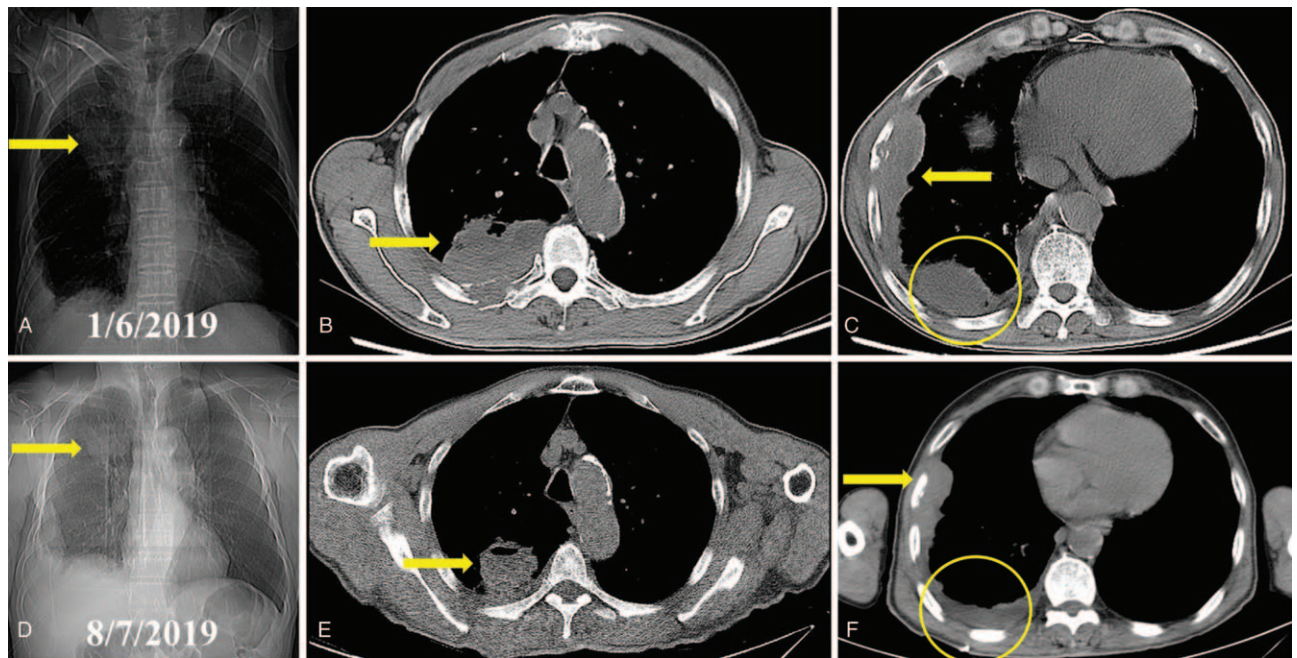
Radiological images of the thoracic lesions (indicated by arrow and circle) before and after systemic treatment in case 3. A. The X-ray showed a bulky mass located in right upper thorax. B. Computed tomography revealed 1 of the pulmonary tumors invading adjacent ribs. C. The other thoracic tumors with osteolytic rib destruction and thickened pleura were shown. D. X-ray indicated a smaller lesion in right upper thorax. E. The tumor showed partial response after 6 months of treatment. F. The other lesions and osteolytic ribs also revealed partial response. CT=computed tomography, PR=partial response.
